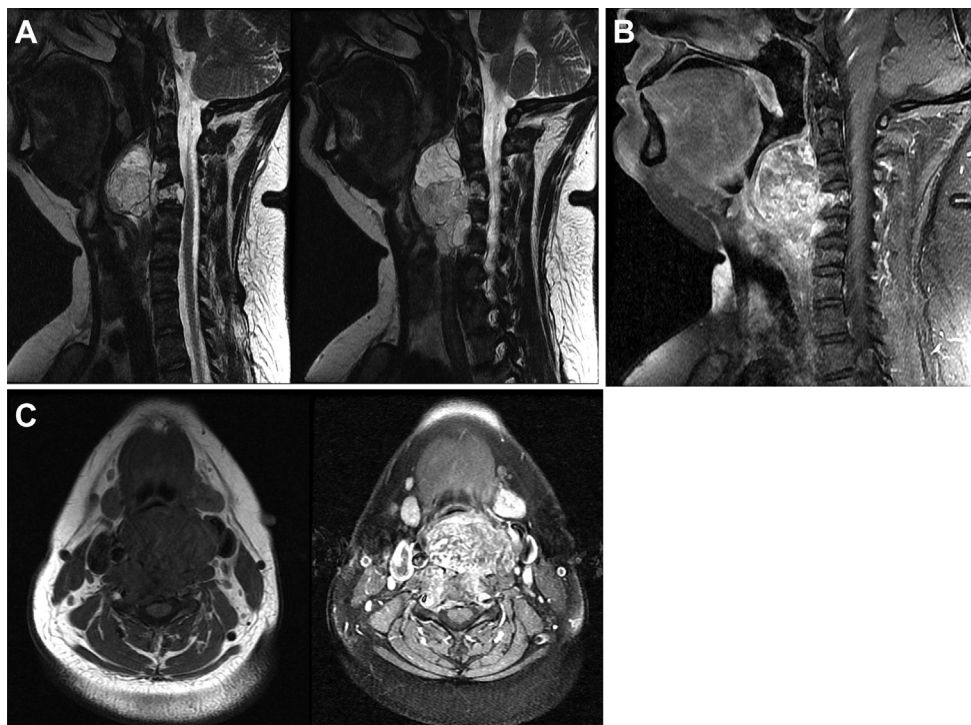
(A) Sagittal T2 magnetic resonance imaging sequence of the cervical spine displaying tumor invasion. (B) Sagittal T1 post-gadolinium injection magnetic resonance imaging sequence of the cervical
